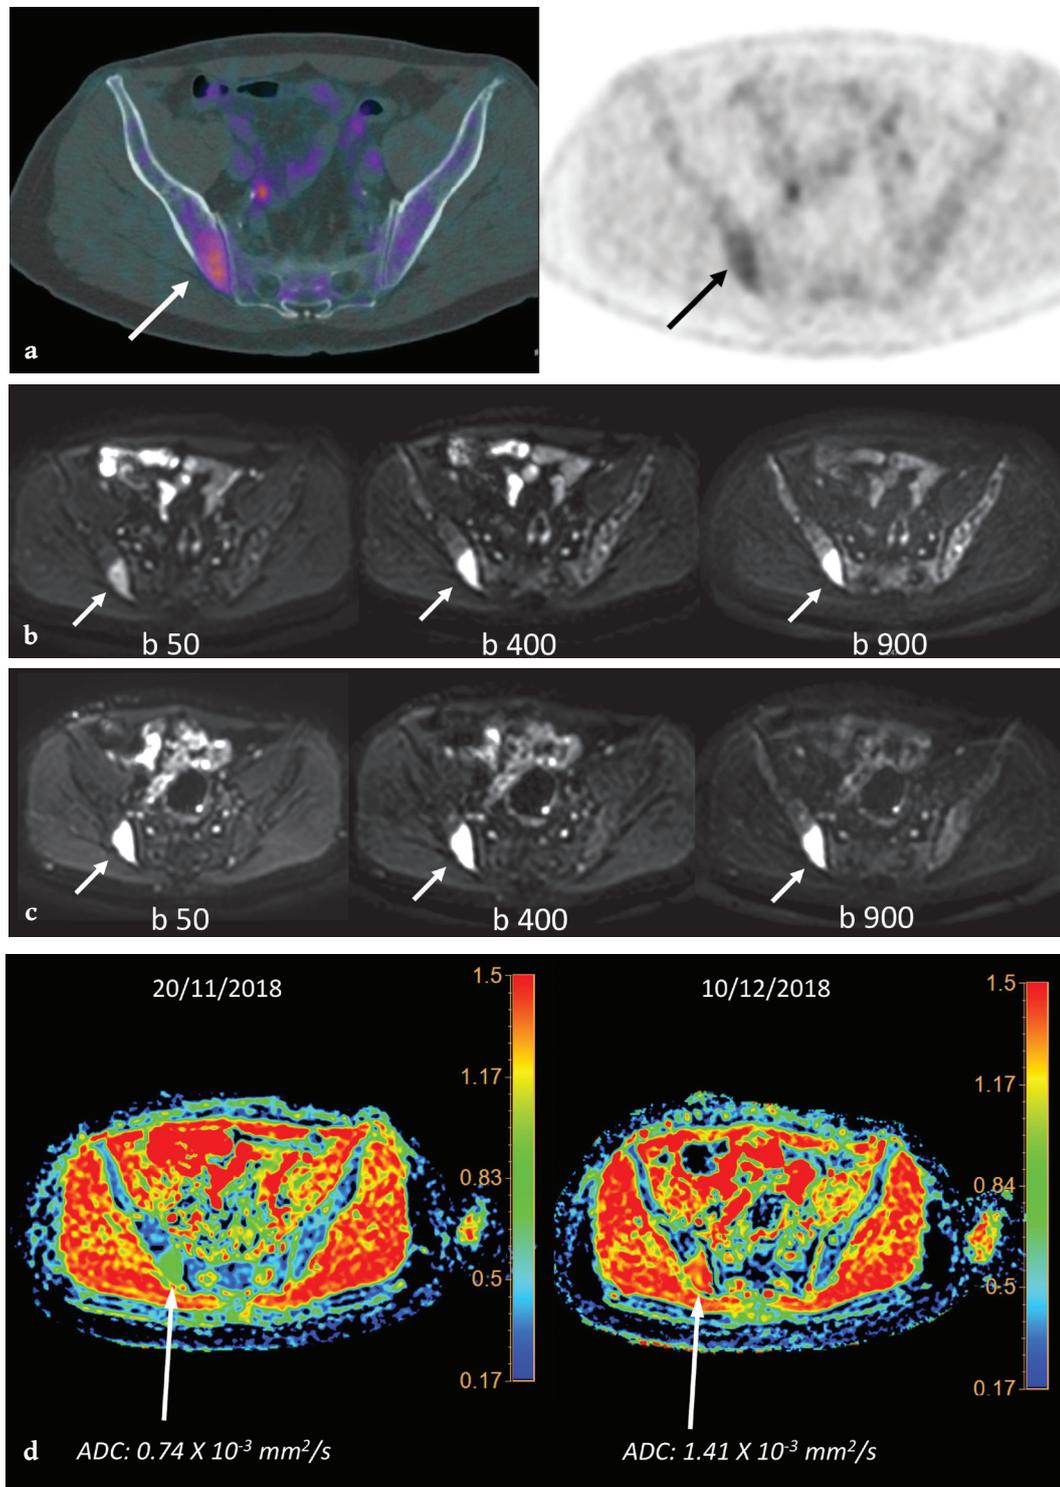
Same patient as in Fig. 2. Pre-treatment axial 18F FDG/PET-CT image of the pelvis (a). Axial DWI of the pelvis (b values 50, 400, 900 s/mm²) acquired before initiation of treatment (b), and three weeks later, after one cycle of VRD (bortezomib, lenalidomide, dexamethasone) (c), with corresponding colour-coded ADC maps (d). The patient achieved very good response to treatment at the time of best response assessment. An area of increased metabolic activity in the right iliac bone (arrow) is shown on 18F FDG/PET-CT (a). On pre-treatment DW images (b) there is restricted diffusivity of the right iliac bone lesion. On post-treatment DW images (c) the signal intensity of the right iliac bone lesion has increased. ADC value of the lesion has risen from 0.74x10⁻³ mm²/s to 1.41x10⁻³ mm²/s after treatment (d).
